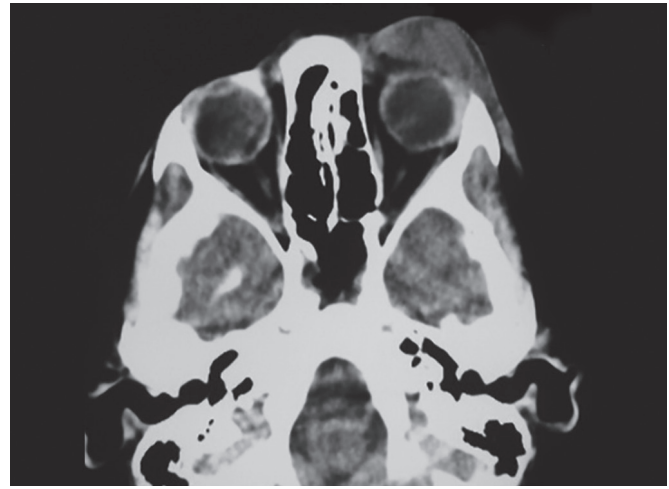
Axial cut CT scan demonstrates the purulent fluid collection on the left. Note its position in the preseptal space. *Courtesy: Daniel Cantero, MD, Santiago, Chile.*
